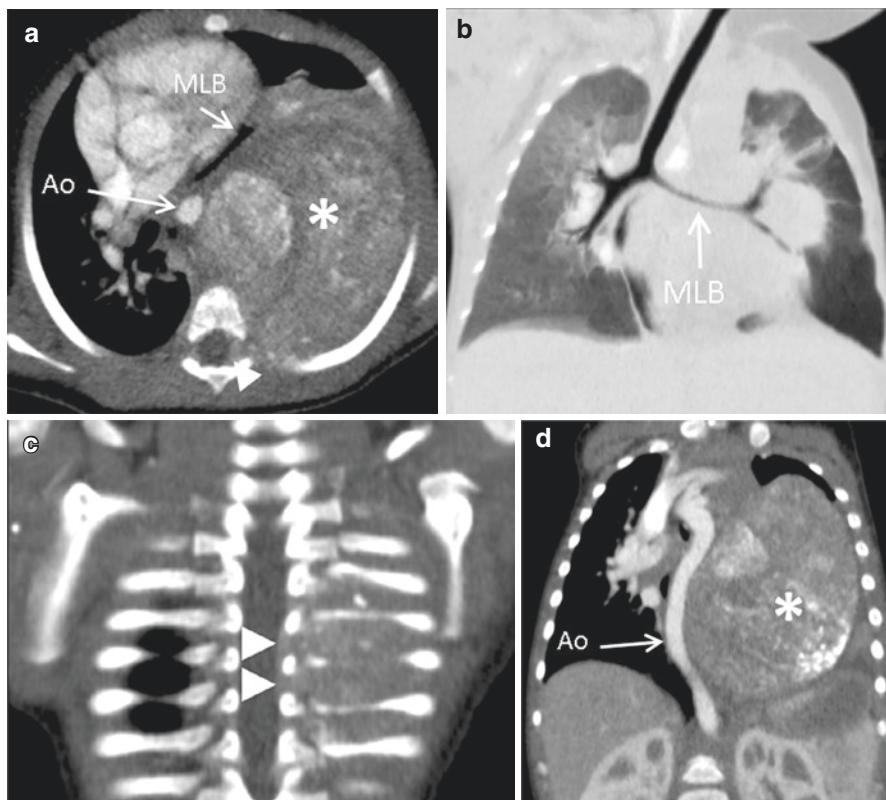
An 11-month-old girl with symptomatic localized left thoracic neuroblastoma. Contrast-enhanced CT scan with transverse view (a) and coronal minimal intensity projection (b) and coronal MPR reconstruction (c, d). The calcified tumor (asterisks) arises from the lower posterior mediastinum (IDRF) and compresses the main left bronchus (MLB) (IDRF). The tumor displaced the descending thoracic aorta (Ao) without encasement (not IDRF) and invades the foramina (arrowheads) and the epidural space of the spinal canal but less than 30% in transverse plane (not IDRF)
